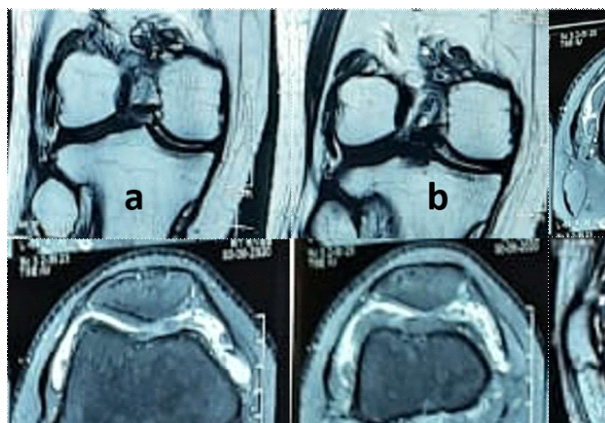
MRI images showing the effusion of knee joint and nodules involving the knee joint. a and b: coronal section images showing nodules and effusion, c and d: Sagittal section images showing nodules in suprapatellar region.
